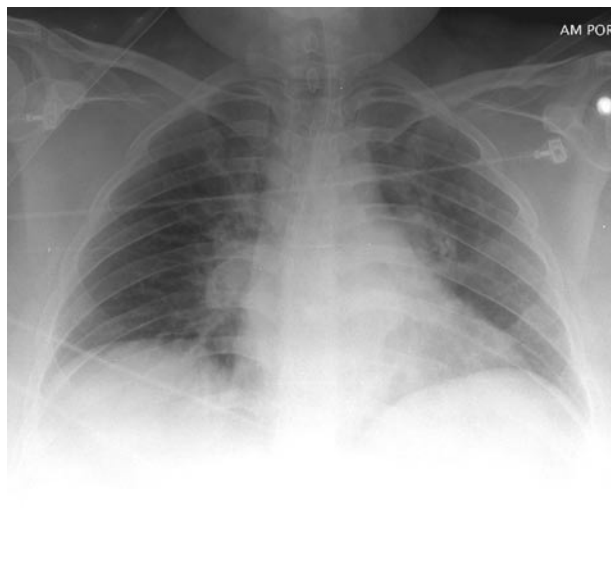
Repeat chest radiograph, 20 hr after the event and after discontinuation of mechanical ventilation, showing resolution of pulmonary edema.
